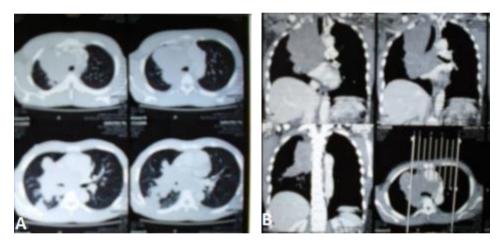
Thoracic CT Scan with contrast: A. Horizontal plane and B. Coronal plane showed a mass at the center of the right lung sized 9.4 x 8.2 x 12 cm penetrating the mediastinum and attached to the posterior thoracic wall. The mass obstructs the superior branch of the right bronchus accompanied by atelectasis, and encase the superior vena cava and right pulmonary artery accompanied by thrombus.
